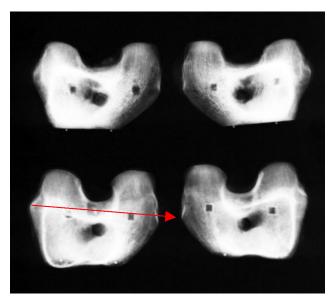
Radiograph shows femoral epicondyles. Radiographic markers on anterior surface of femur were used to compare and measure amount of femoral rotation after resection to transepicondylar axis.
